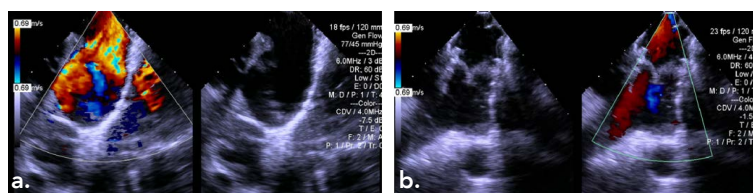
Intracardiac echocardiographic images of the RVOT before and after the intervention. Note the absence of leaflet tissue and free regurgitation (a) as indicated by color flow Doppler prior to placement of the Alterra Adaptive Prestent™ and Sapien 3 valve compared to following the implant (b).
